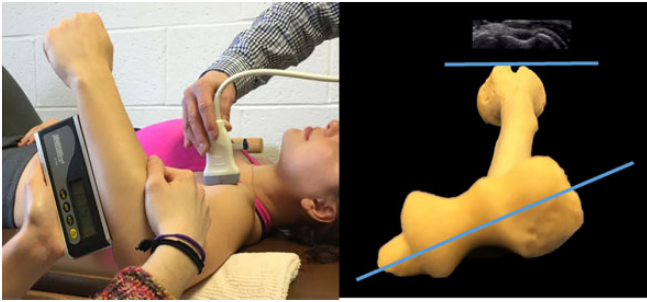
Measurement of humeral retrotorsion (HRT). The apices of the greater and lesser tuberosities were identified via ultrasonography and aligned horizontally. The angle of the ulna relative to horizontal was measured representing the difference in alignment between the humeral head and transepicondylar axis (degree of HRT). Higher values indicate greater degree of HRT.
